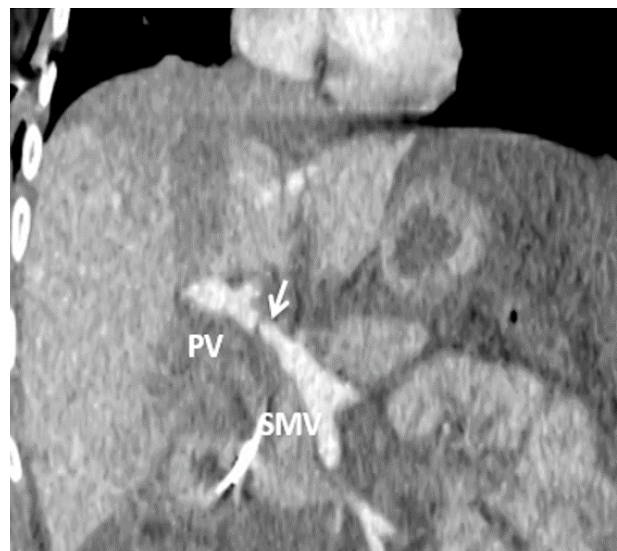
Female patient, 40 years old, first day after orthotopic liver transplantation. Computed tomography image portovenous phase multiplanar reconstruction, acute occlusive portal vein thrombosis occurred. PV – portal vein; SMV – superior mesenteric vein; SV – splenic vein; PSS – portosystemic shunts.
